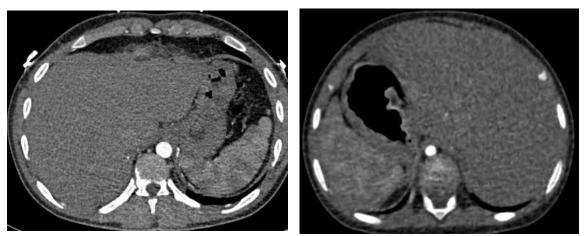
A- CT axial MIP image shows the largest lobe of liver at the right side and stomach and spleen at the left side, which is regarded as situs Solitus {S, _, _}.
